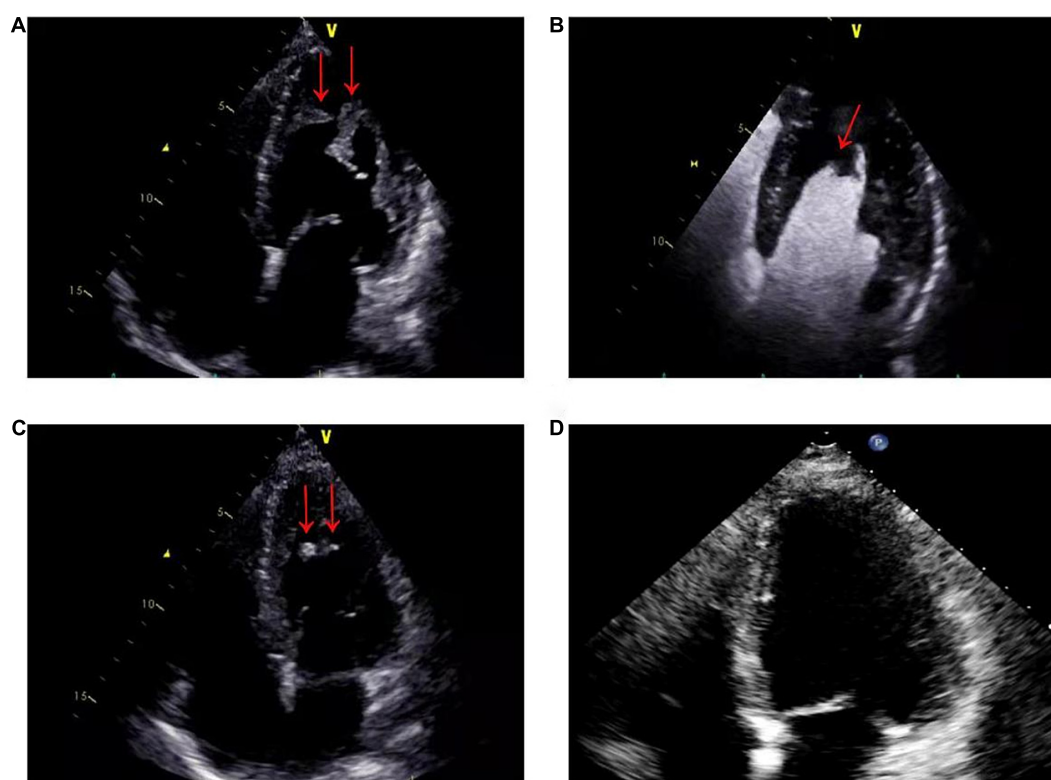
(A) On admission, echocardiography showed that the apex of the left ventricle was filled with a thrombotic mass measuring 3.9 cm × 2.2 cm (arrows). (B) On admission, echocardiographic view after venous injection of an ultrasound contrast agent: thrombus (arrow) at left ventricle apex. (C) Two months after therapy, echocardiography showed a marked reduction in the size of the mass, with a thrombotic mass measuring 6 mm × 13 mm (arrows). (D) Six months after therapy, echocardiography showed that left ventricular thrombus had resolved.
